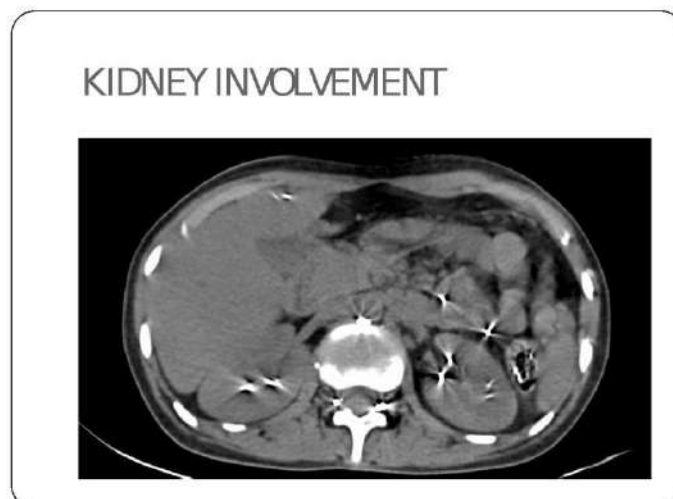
shows a CT abdomen with dense radio opacities in both kidneys.
